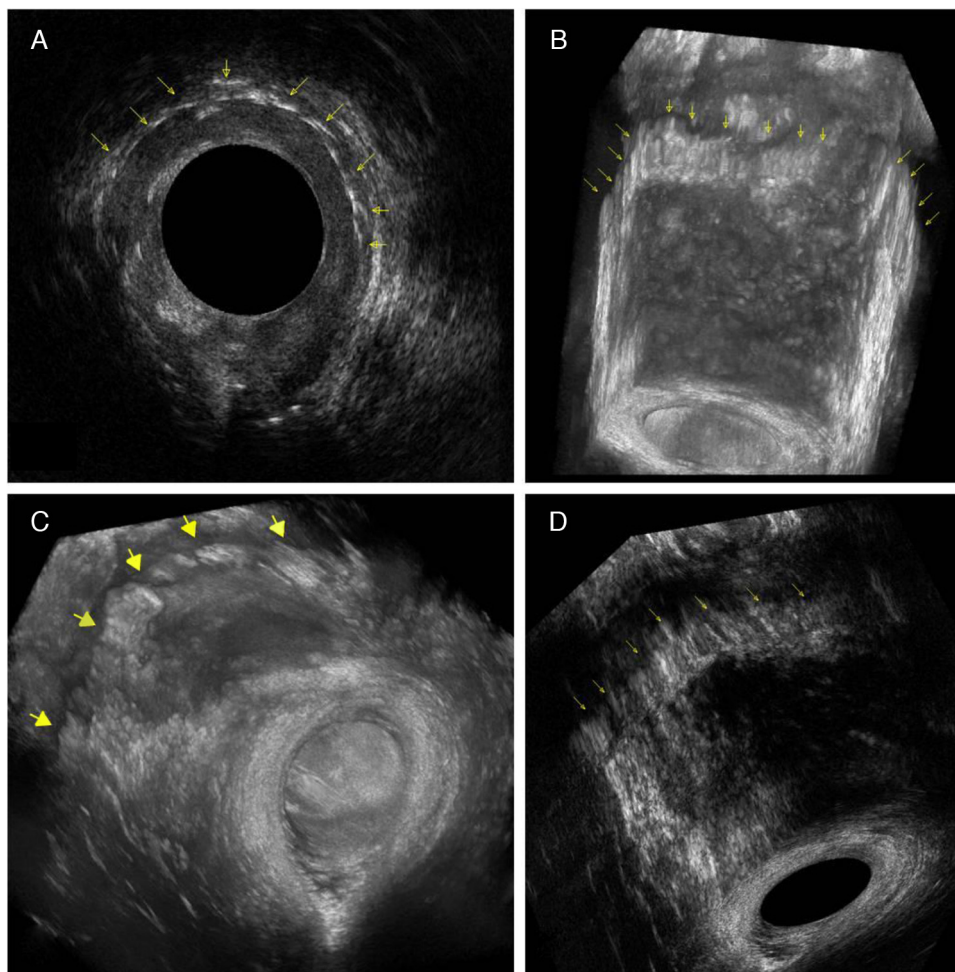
360° tridimensional transanal ultrasound: yellow arrows indicate the staple line. (A) 2D visualization; (B, C) 3D visualization with rendering; (D) 3D visualization.
